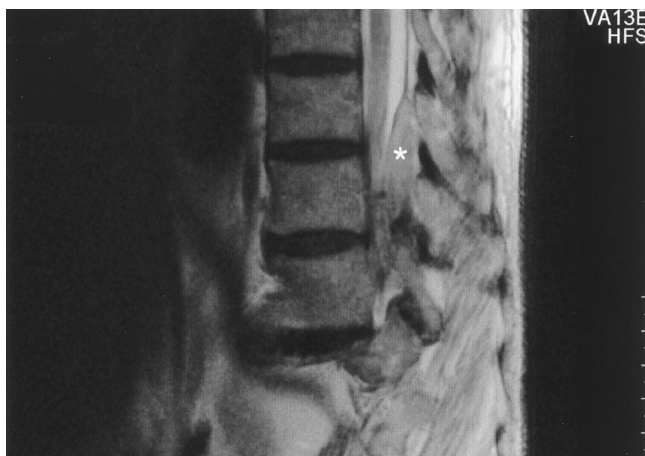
Sagittal magnetic resonance imaging section at the T12–L1 level after removal of an epidural catheter revealing an epidural mass (*) extending from T12 to L1 compressing the dural sac.
